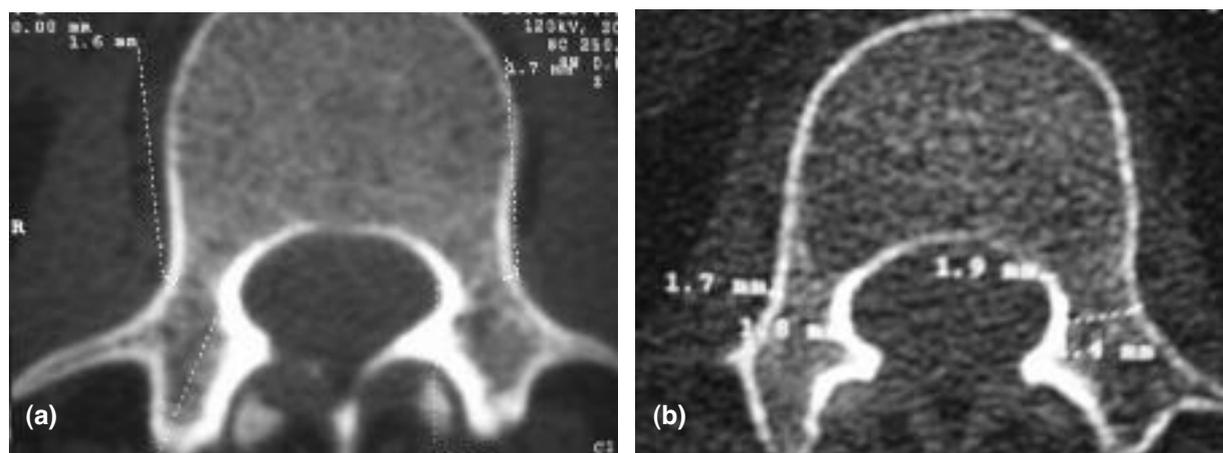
a.-b. Axial CT show the pedicles, the medial pedicle cortical walls are more thicker than their lateral walls.
